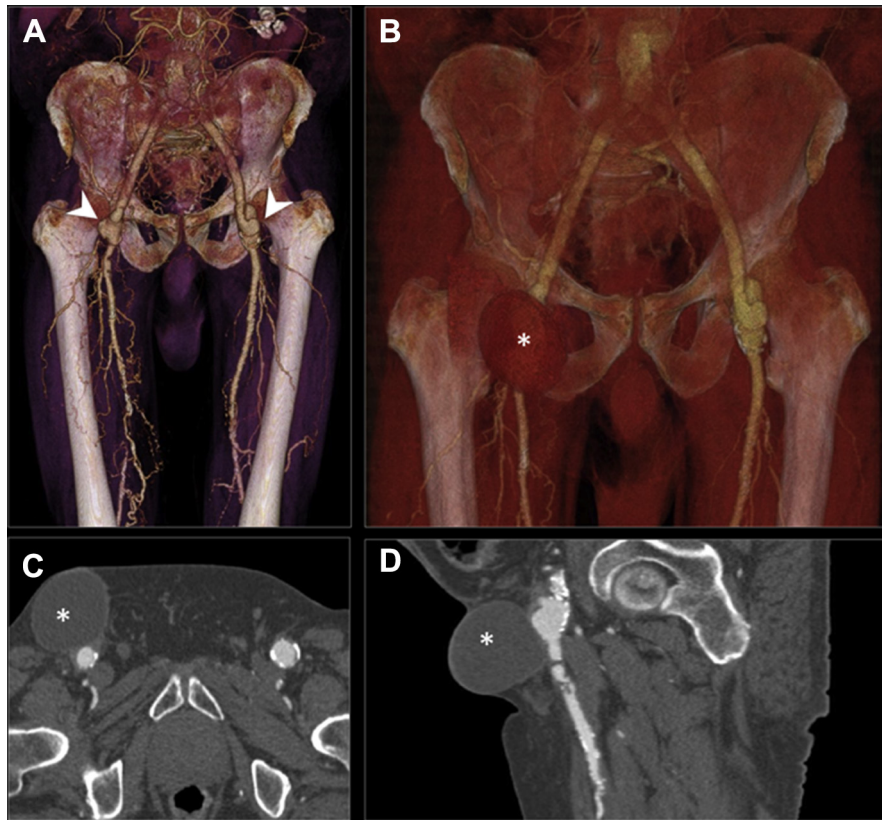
CT angiogram of a 79-year-old male patient previously treated with aortobifemoral bypass due to bilateral obstruction of the common and external iliac arteries (TASC D). Three weeks after treatment, right inguinal swelling occurred. Frontal volume rendering image (A) demonstrates bilateral small pseudoaneurysms at the femoral anastomotic sites (arrowheads). The soft-tissue visualization setting applied to the same image (B) shows a round mass at the right inguinal wall (asterisk). Hypodense perivascular collection (asterisk) is confirmed on both transversal Multi Planar Reconstruction (MPR) (C) and curved planar reformation (CPR) (D) images. The findings indicate a subacute seroma. Treatment is not required because of the absence of compression on the vascular structures.
